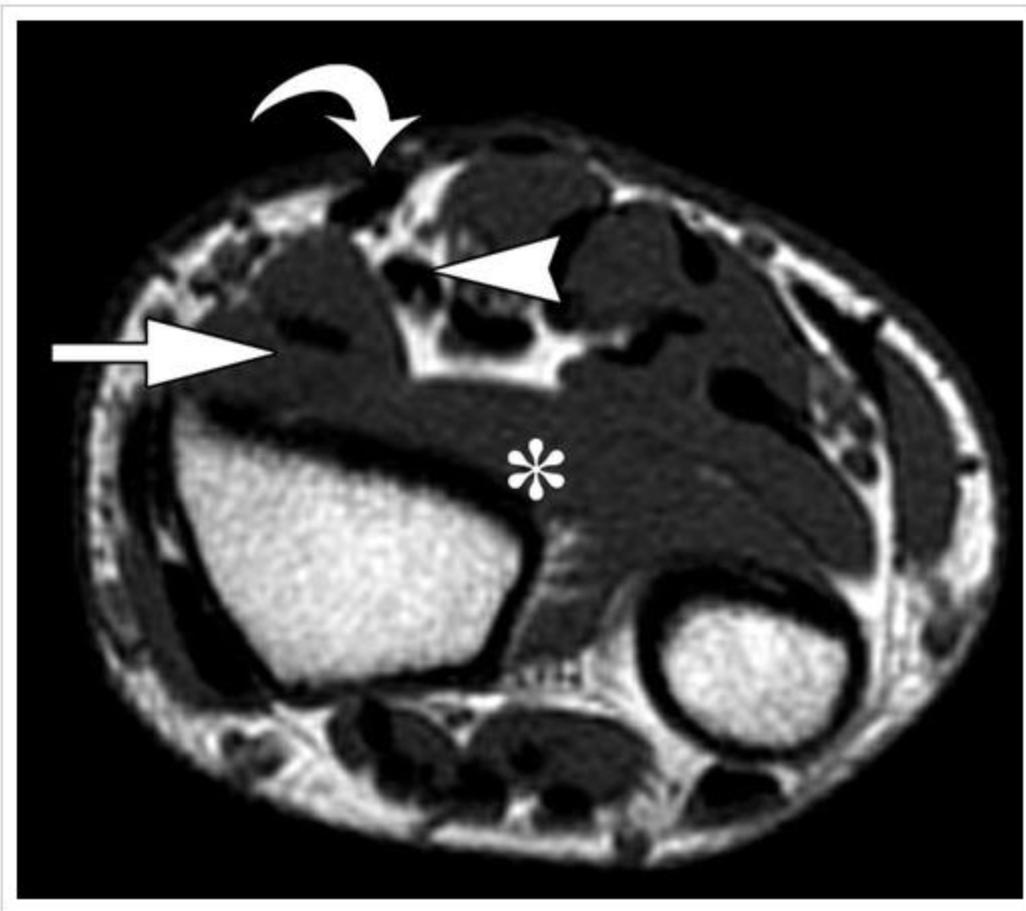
FCR brevis vel profundus in a 22-year-old patient who presented with volar soft-tissue swelling. Axial T1-weighted MR image of the wrist shows no masses, but a prominent accessory muscle (straight arrow) is seen deep to the FCR (curved arrow) and superficial to the pronator quadratus (*) on the radial aspect of the FPL (arrowhead).
